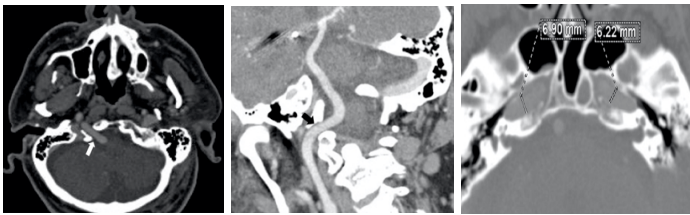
60-year-old man with persistent hypoglossal artery. On the axial (a) and oblique (b) reformatted CT images, persistent hypoglossal artery passes through the widened right hypoglossal canal. Axial CT image (c) shows widening of the carotid canal.
